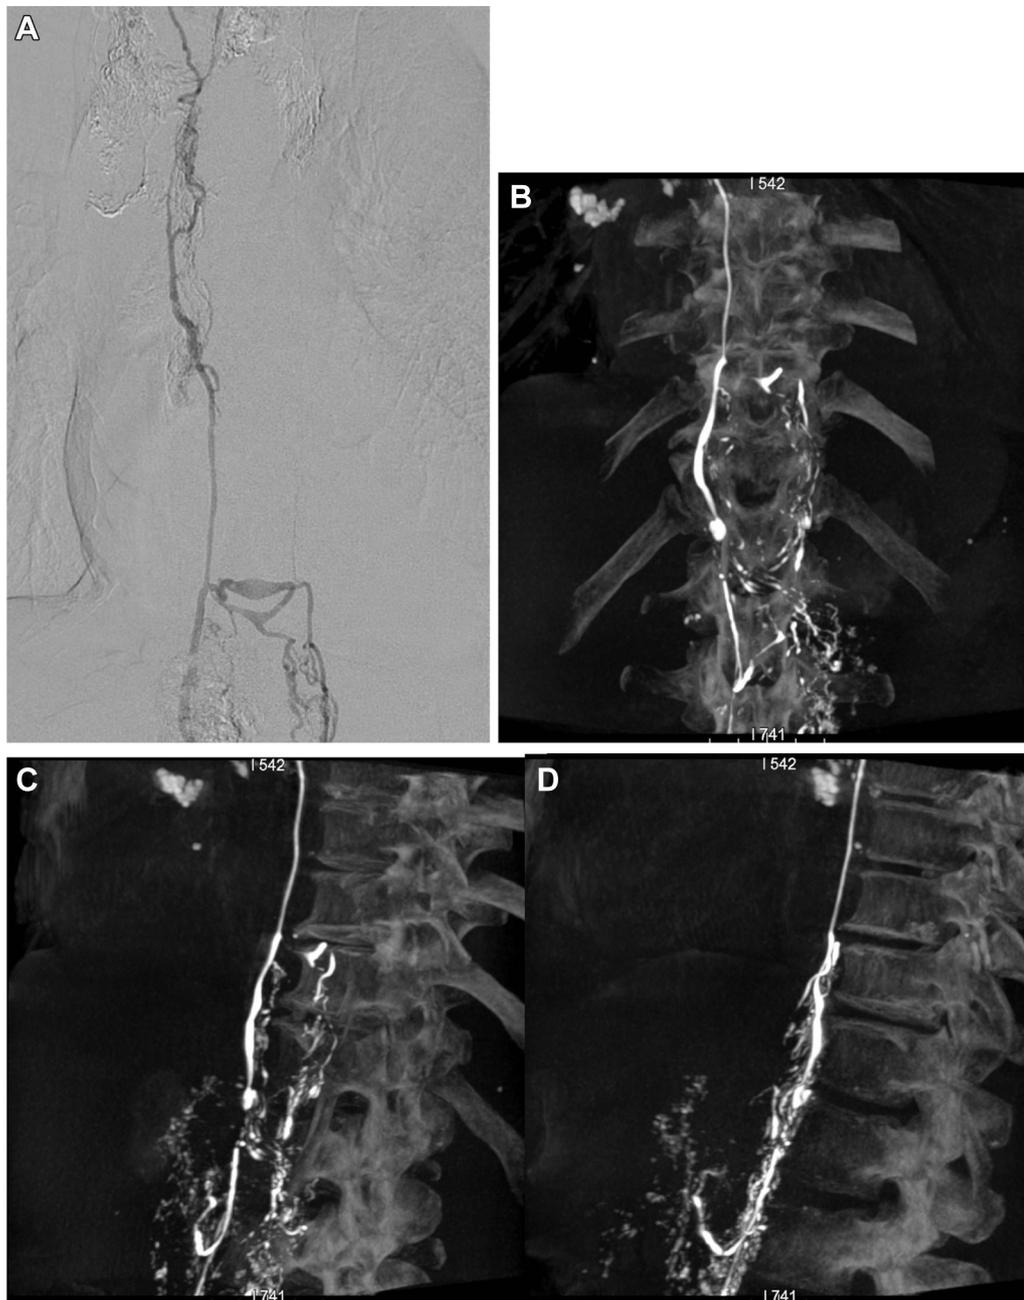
Opacification of the thoracic duct (TD) revealed no visualized leak to the pleural spaces. A, Conventional digital subtraction angiography lymphangiogram of the chest and upper abdomen demonstrates no clearly visualized leak. B-D, Anteroposterior, left anterior oblique, and lateral projections from a cone beam computed tomography (CT) lymphangiogram of the chest also confirm no clearly visualized leak.
